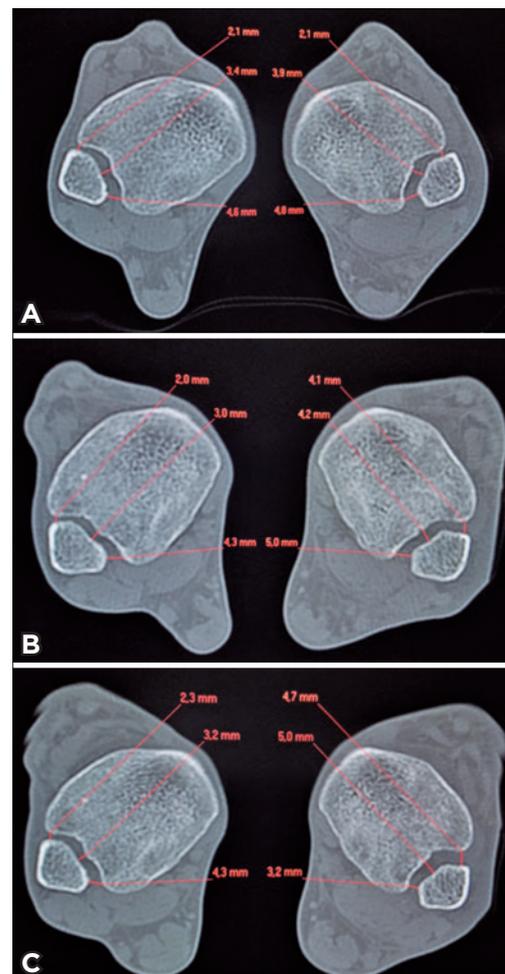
CT images in the axial plane 1 cm above the tibial plafond during the three phases of the examination. CT in the neutral position (A). CT with ankle stress maneuvers and extended knees (B). CT with ankle stress maneuvers and semi-flexed knees (C).
